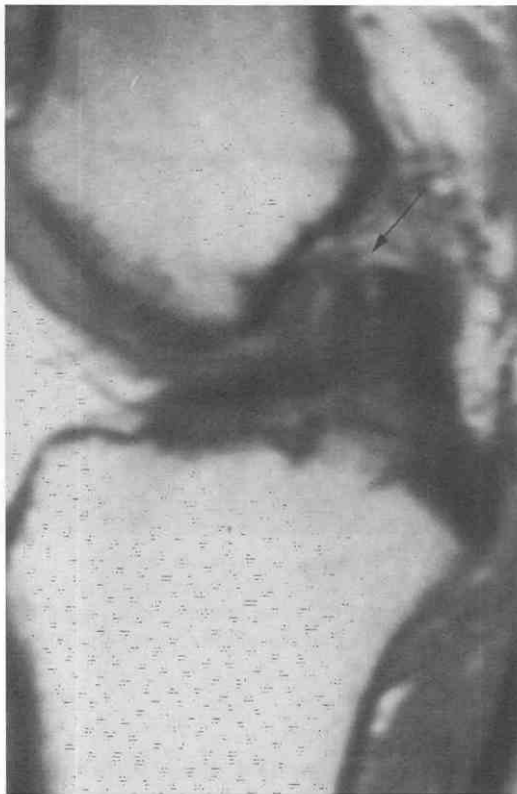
Anterior cruciate ligament (ACL) tear. Sagittal T1-weighted image shows buckling of the ACL, with increased signal intensity at its proximal portion, consistent with a tear (*arrow*).
